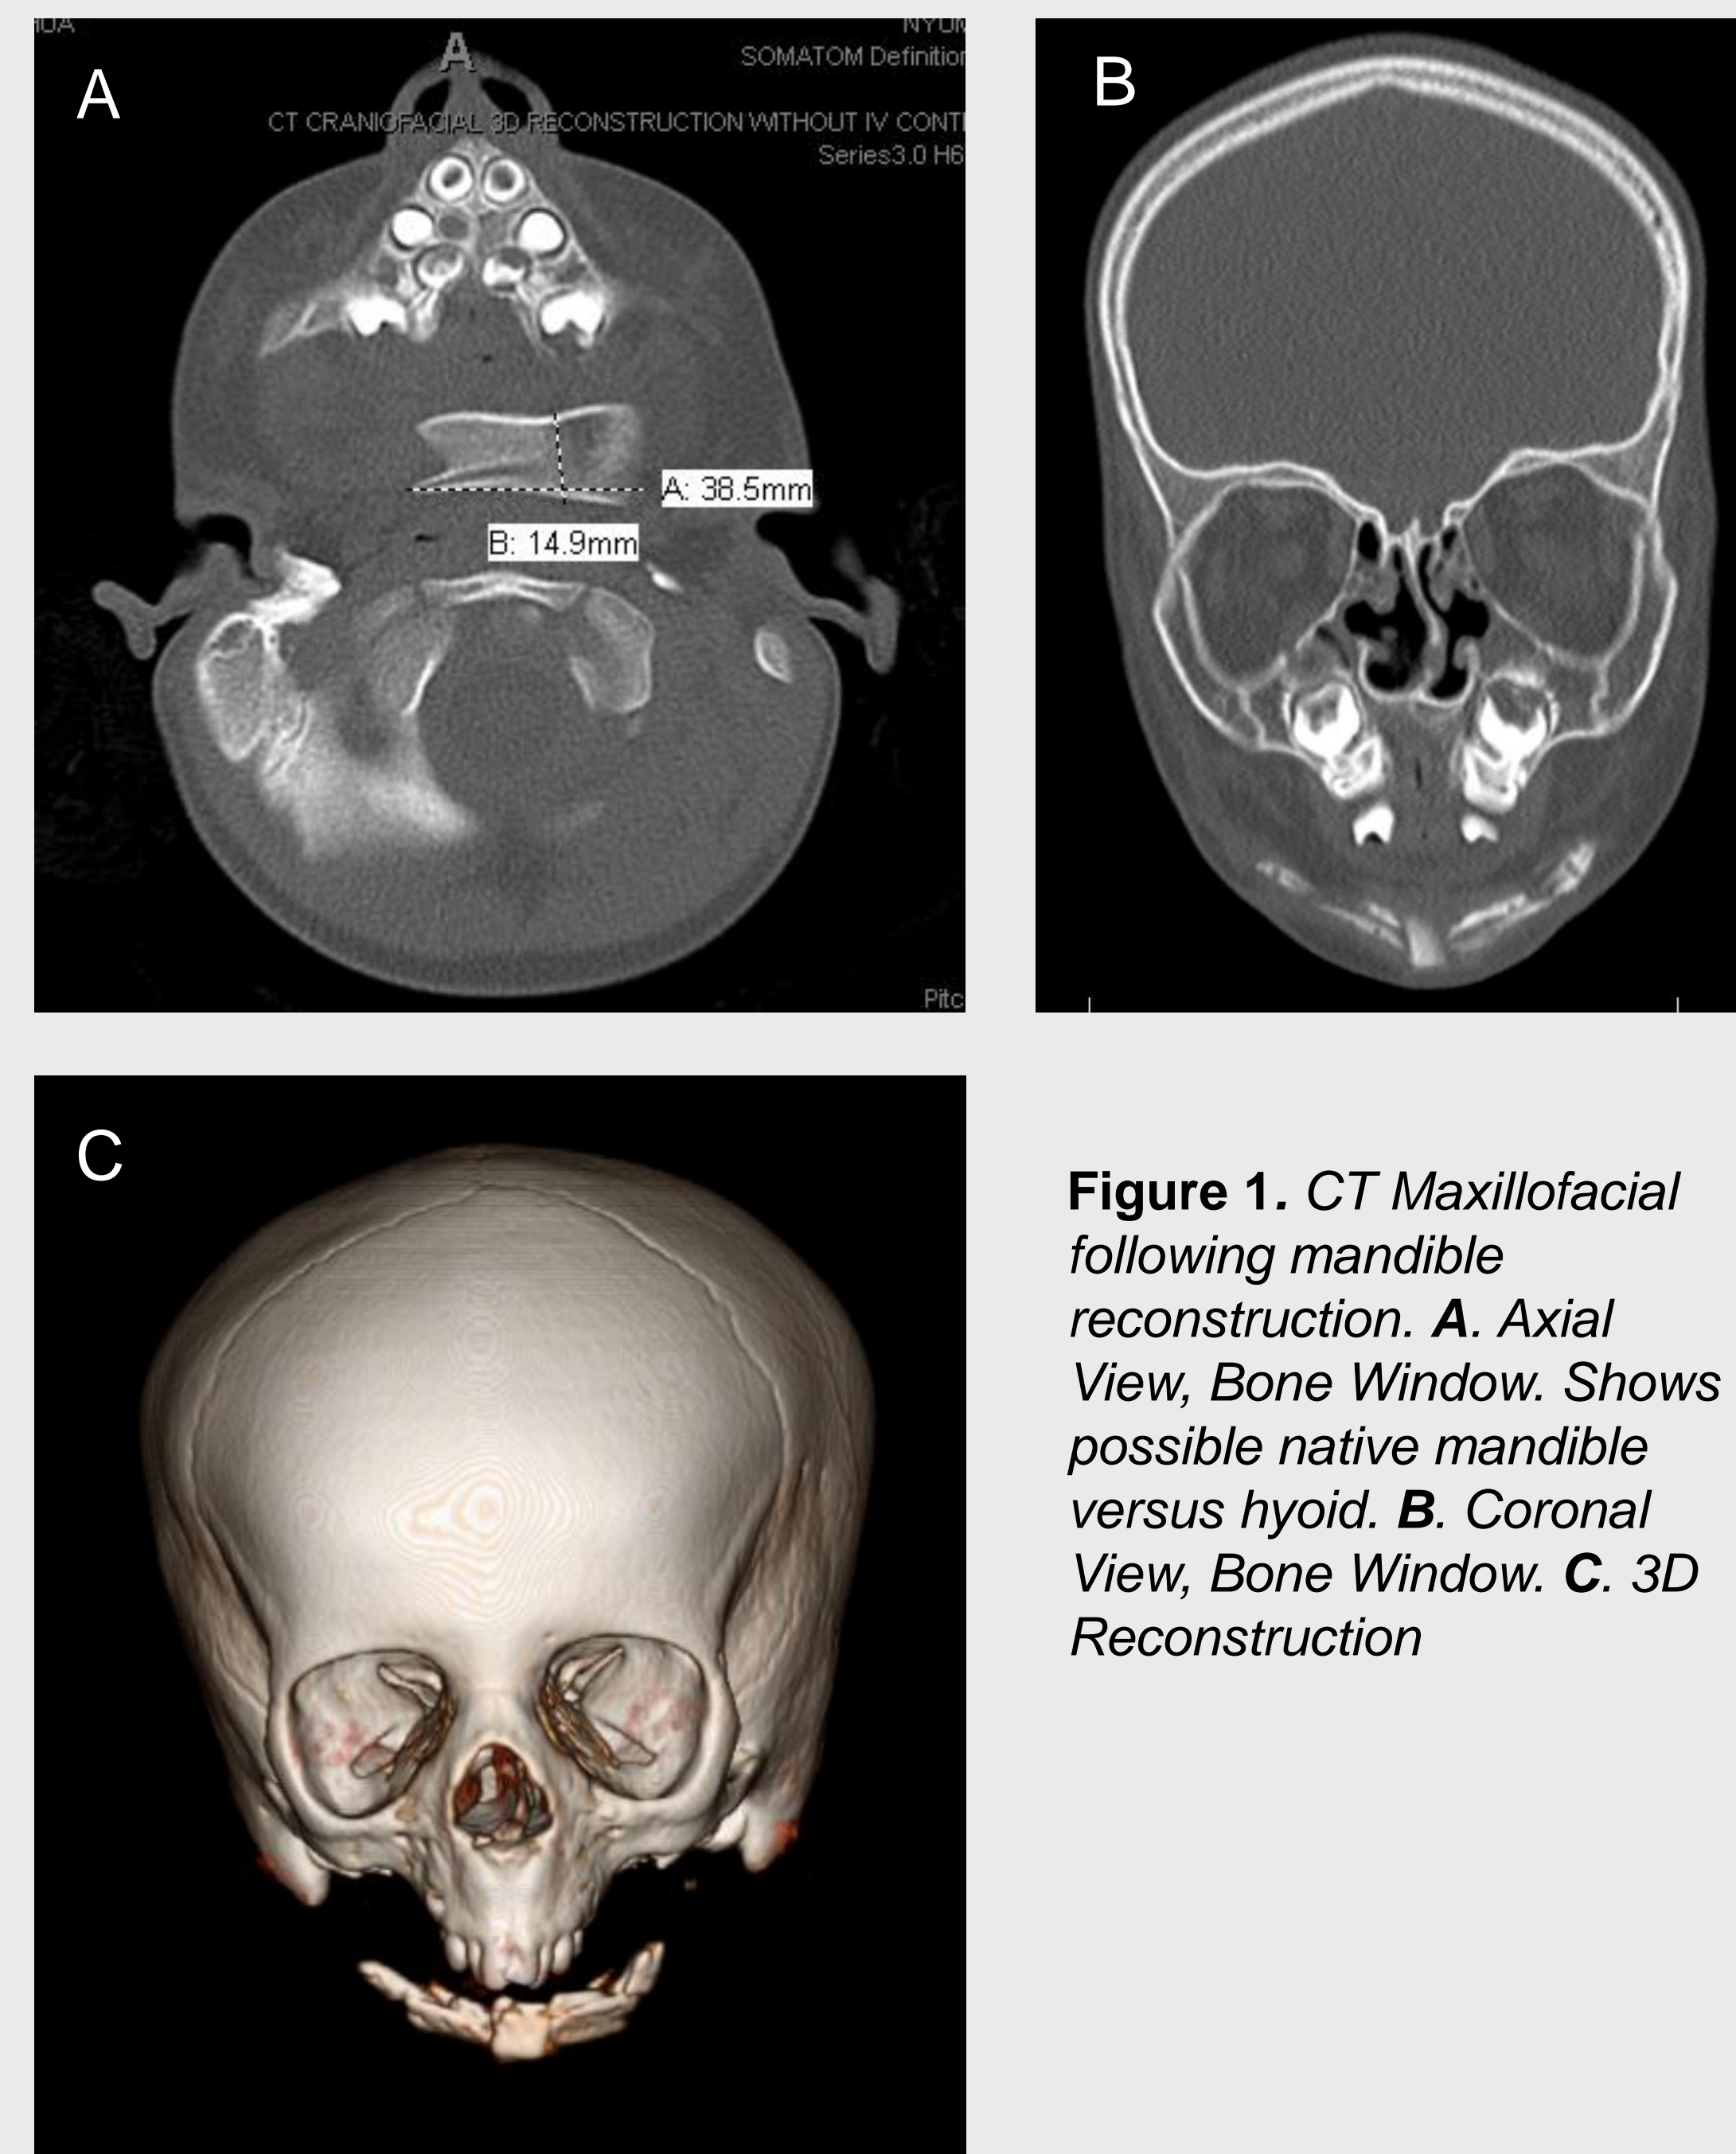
CT Maxillofacial following mandible reconstruction. A. Axial View, Bone Window. Shows possible native mandible versus hyoid. B. Coronal View, Bone Window. C. 3D Reconstruction
